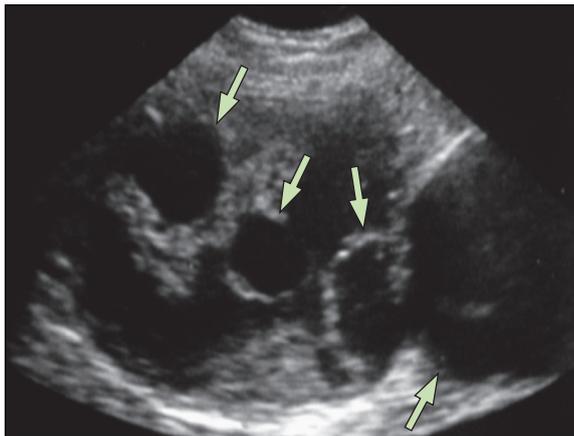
Mesenteric lymph node cavitation in a patient with refractory coeliac disease complicated by ulcerative jejunoileitis and splenic atrophy. Multiple cavitations of mesenteric lymph nodes appear on abdominal bowel sonography as anechoic cystic masses with posterior acoustic enhancement (arrows).
